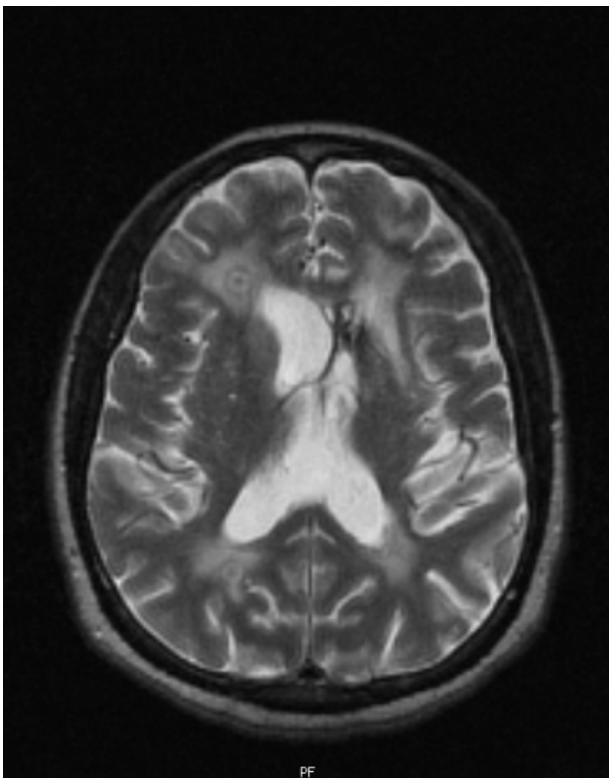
CT scan of the brain showing two lesions with a ring shaped enhancement.
